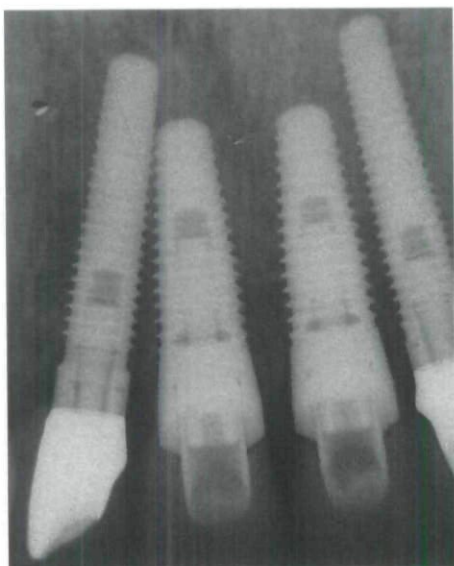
Radiographic view of definitive restorations.
